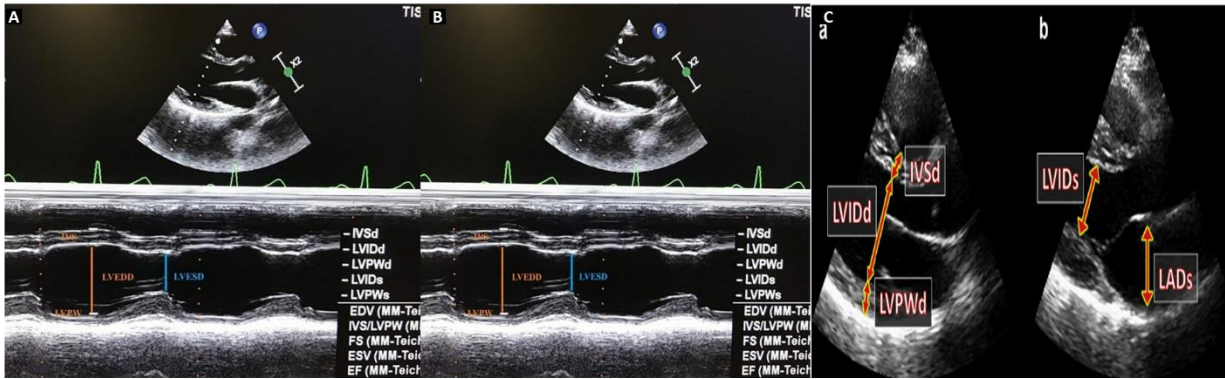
M-mode Echocardiography, 2D Cardiac Measurements (A), Echocardiography, measurement of Left Ventricular Mass (B), and Parasternal long axis view showing measurement of Left Ventricular Mass (C)
